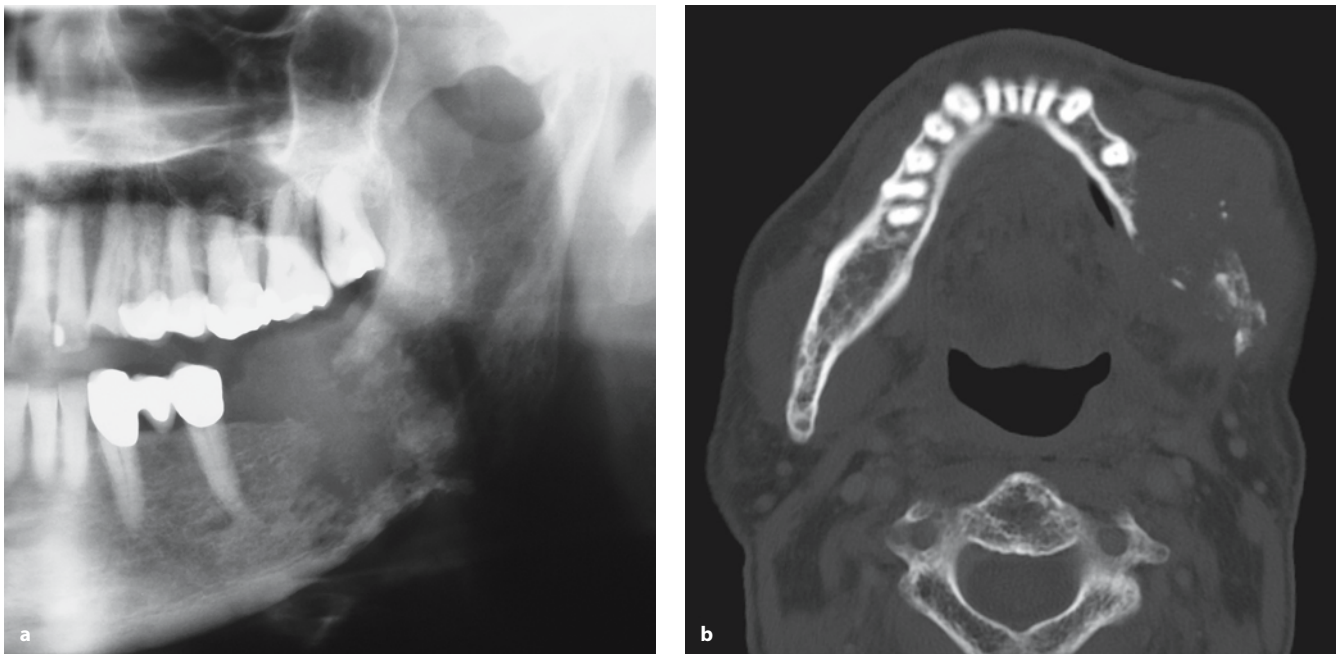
A 56-year-old man diagnosed with a recurrent squamous cell carcinoma of the left mandible with infiltration of the buccal mucosa. Pre-operative panoramic X-ray (a) and axial CT (b) show the lesion. Note that application of an individual reconstruction template on the mandible is not possible due to extensive soft tissue infiltration (patient T.H.)
